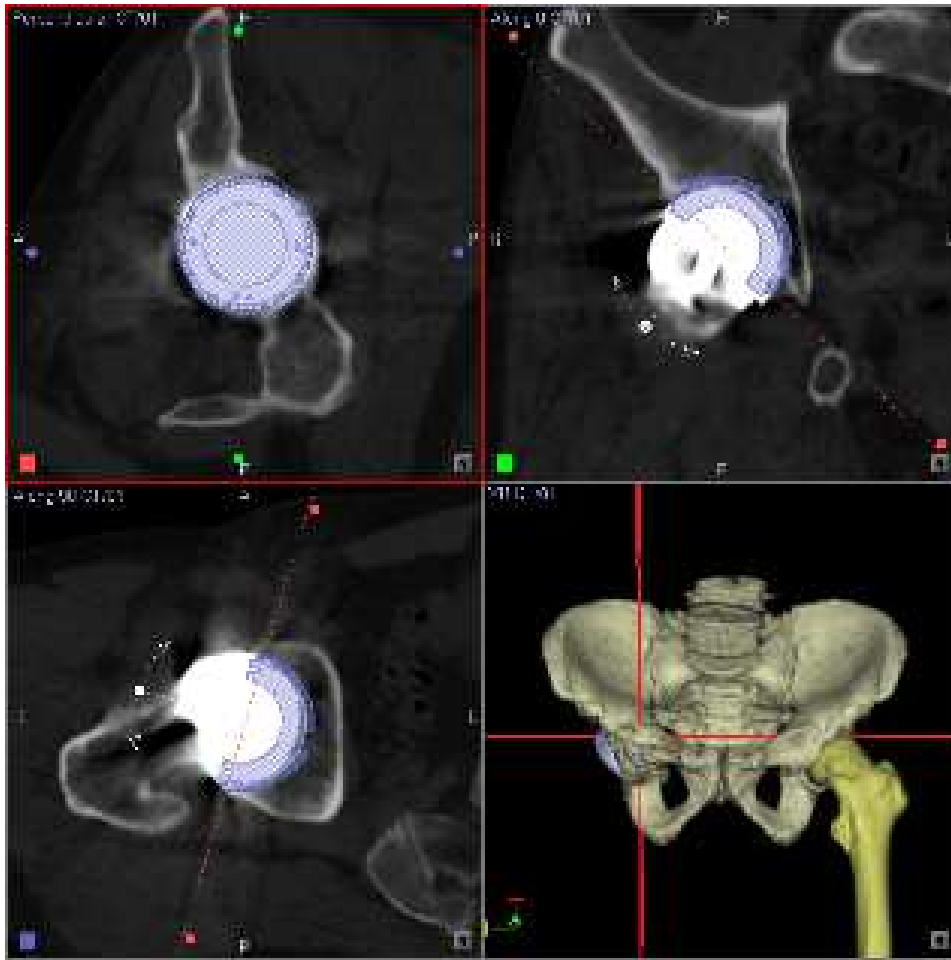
A cup computational model was overlapped on the postoperative CT data to assess the accuracy of cup placement using postoperative CT data. The pelvic reference coordinate was matched with the preoperative pelvic coordinate using the landmark-matching method
